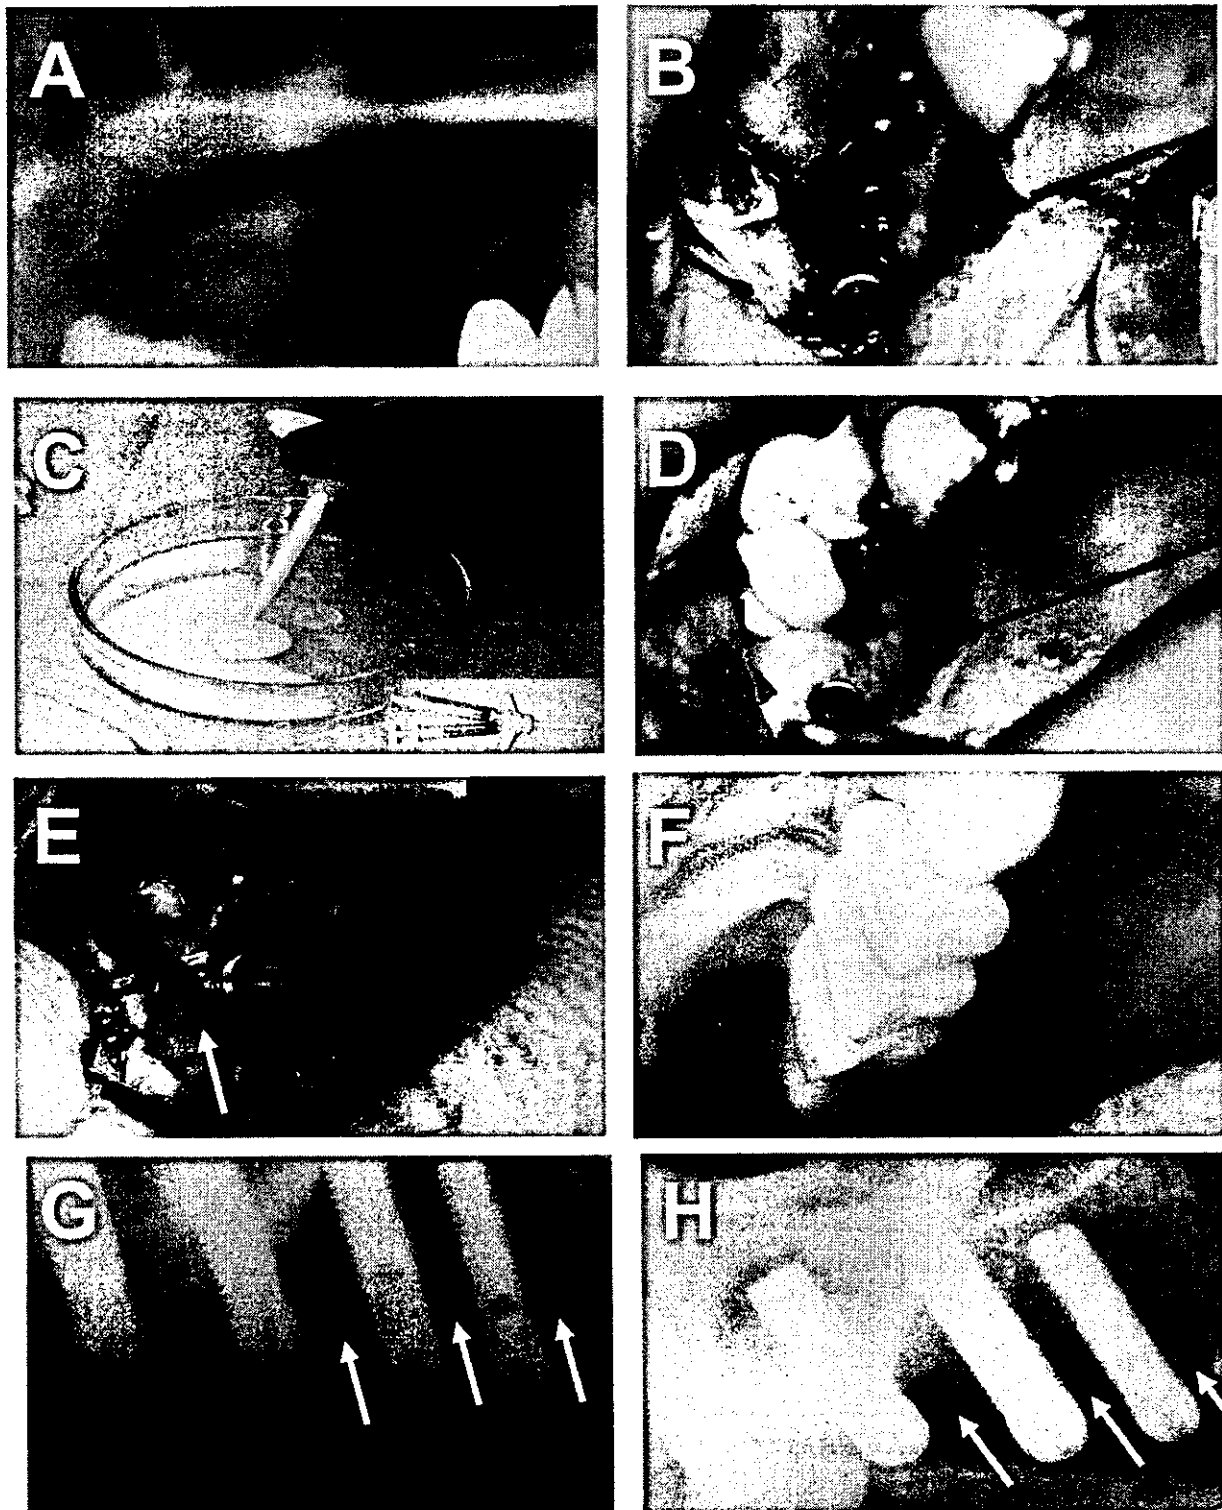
(A) Panoramic radiograph of the patient, preoperative. (B) Macro view of a 15-mm Ti-blast titanium dental implant insertion into a prepared implant site. (C) Preparation of injectable bone by injectable instrument and two syringes. (D) Macro view of a tissue-engineered bone insertion. (E) Observation of second-stage surgery 6 months after the implant installation. The exposed thread was surrounded by newly formed bone (see the arrow) and confirmed successful osseointegration. (F) Last prosthesis observation by porcelain fused to a metal crown. (G) A periapical radiograph after a postoperative time at 1 week; the radiolucent area around the installed dental can be found. Arrow shows the radiolucent area. (H) A periapical radiograph after a 6-month period; the radiograph shows a bone fill within the infrabony defects and around the previously exposed threads, reaching the neck of the implants (see the arrows).
